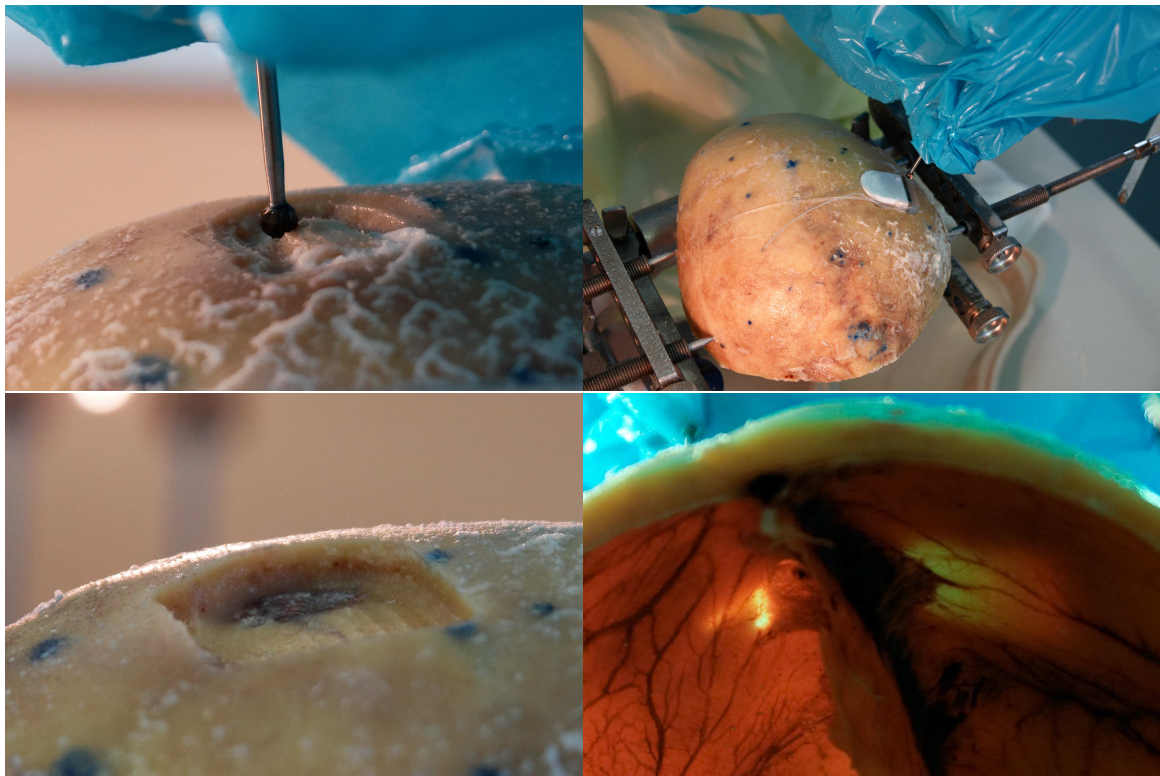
Robot-based milling of a generic implant bed in a human skull preparation for the Combi40+ geometry model (top left) based on a 3D ultrasound map (performed with the CASPAR/RX90 robot). The implant fits the later cavity within very tight limits (top right). After milling, the precise pre-operative positioning of the milling volume becomes apparent as the dura mater is just visible (bottom left). Viewed from below, the thin remaining bone layer lets light shine through, with the sensitive dura mater-perfusing blood vessels intact (bottom right).
